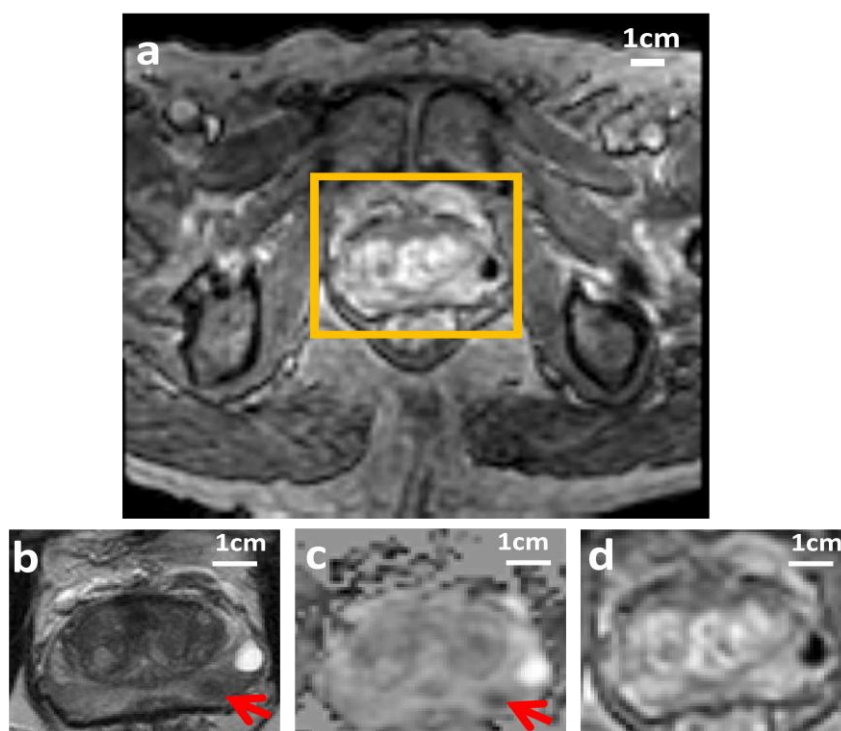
a) Full field of view of the DCE-MR images which shows the prostate region used in ICA analyses (yellow box), b) the T_2 -weighted image, c) the ADC map, and d) the prostate in the DCE-MR image of the prostate. The cancer in the peripheral zone of the prostate which appears as a hypo-intense region in T_2 -weighted image and ADC map is identified with red arrows.
